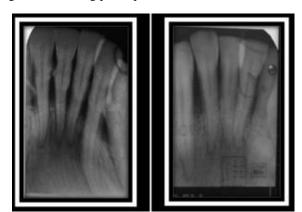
Intraoral panoramic radiograph 21,31 region pre and post treatment
